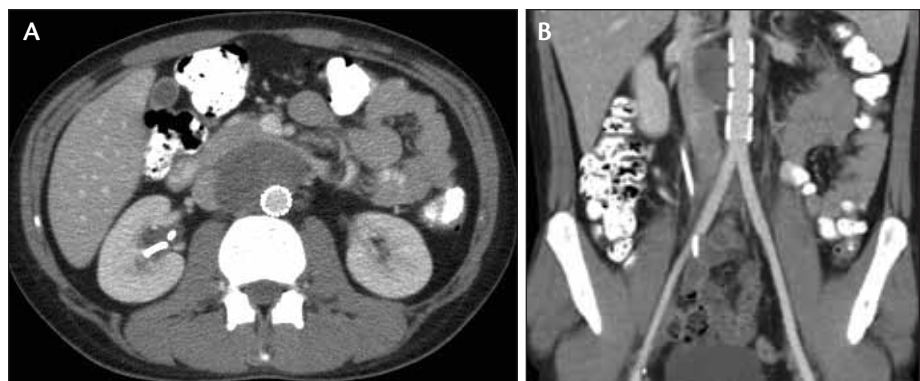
Axial slice (A) and coronal slice (B) of a postoperative CT angiogram. There is complete exclusion of the false aneurysm and satisfactory position of the stent graft with reduction in size and vascularity of the surrounding tumor.
